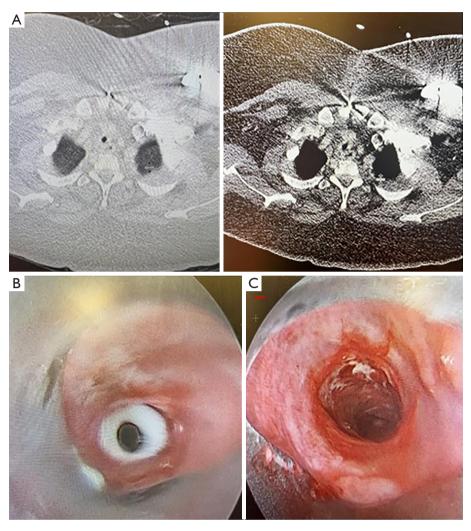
Radiographic and bronchoscopic images and patient with post tracheostomy tracheal stenosis. (A) Axial CT images demonstrating severe stenosis of the proximal trachea. (B) Initial inspection with rigid bronchoscopy. (C) Post radial incisions and initial dilation. CT, computed tomography.
